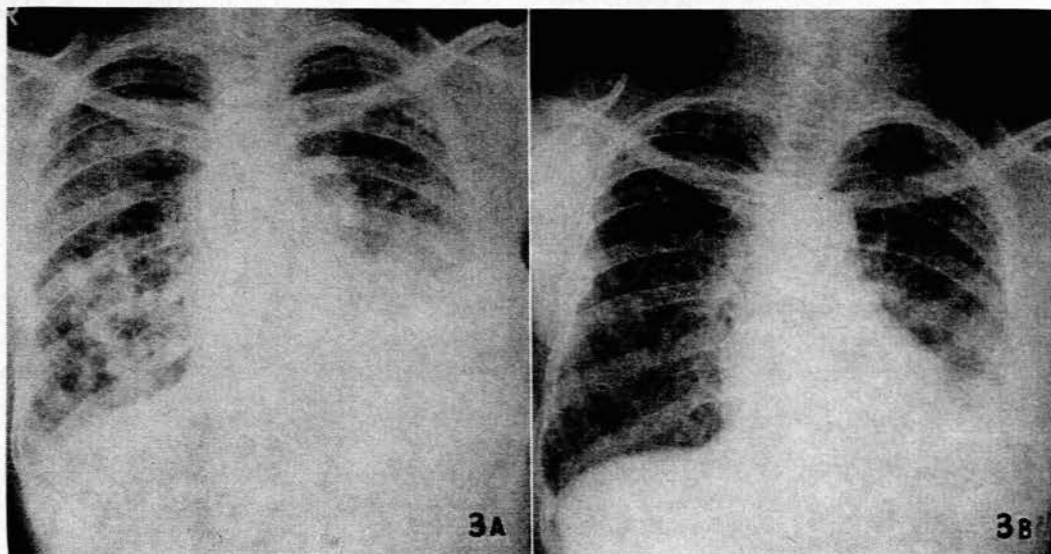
Patient with extensive lung secondary deposits. A. Chest X-ray in February 1958, shortly before ovarian irradiation. B. Chest X-ray in November 1958. Note marked improvement in appearance of the lungs.
